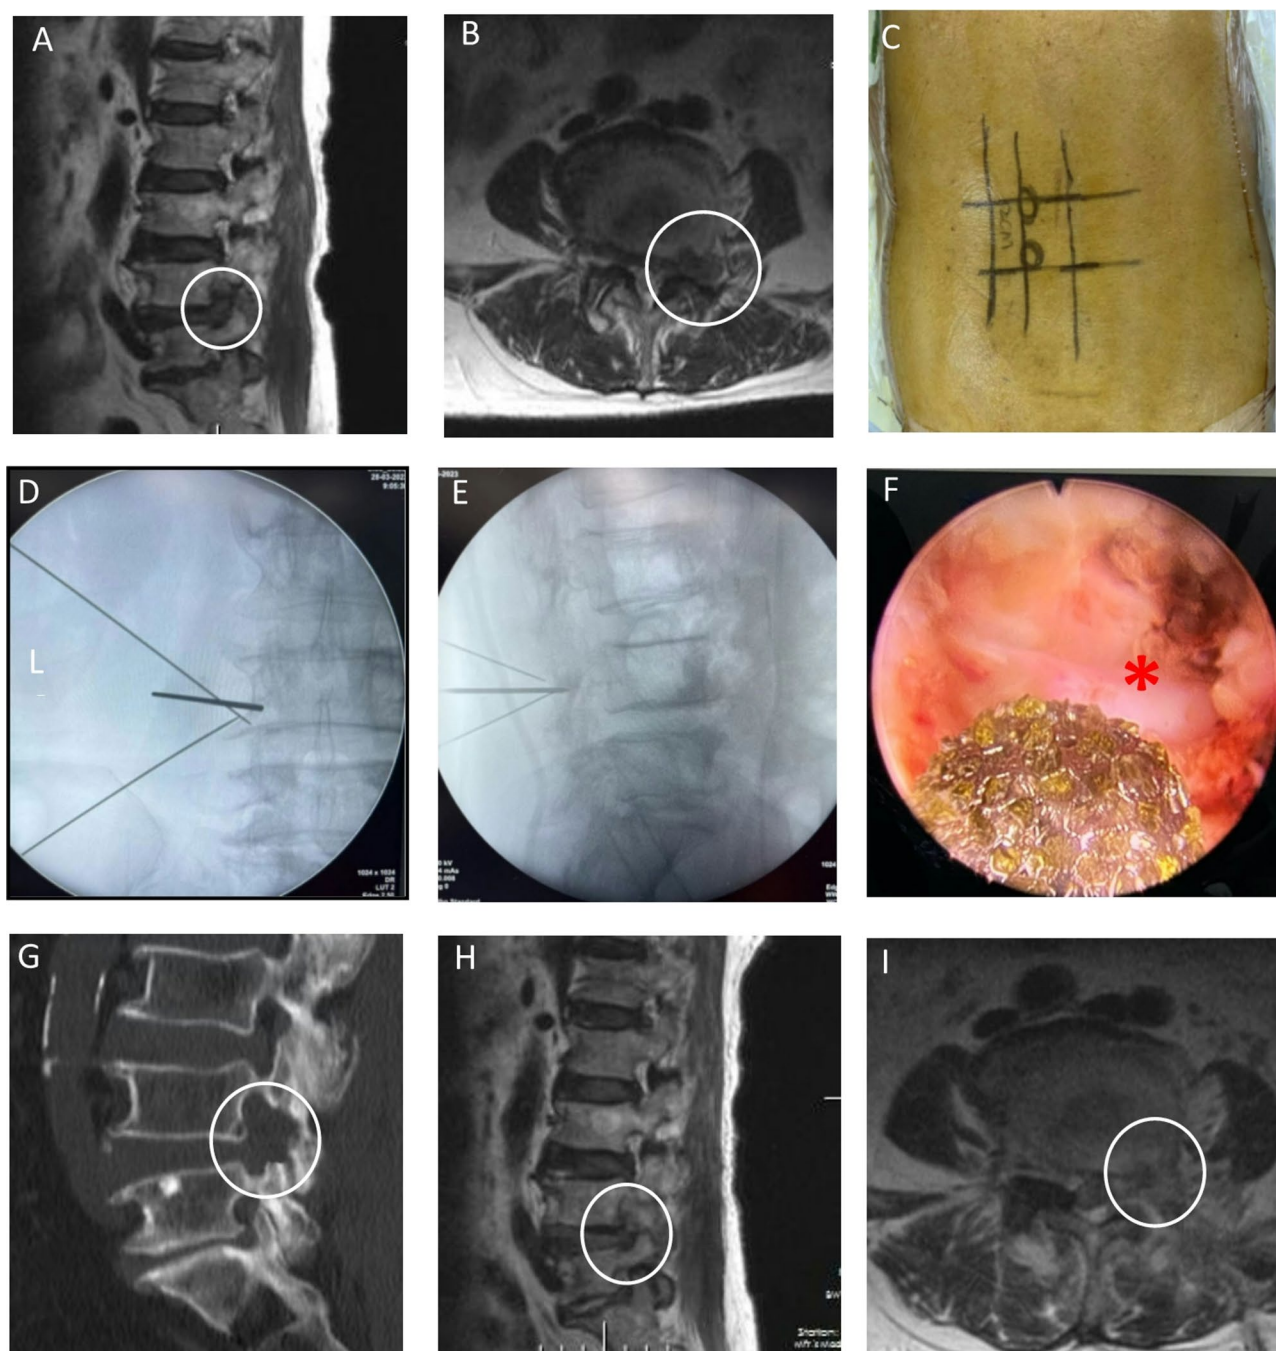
A 55-year-old male patient diagnosed with L4-5 far lateral lumbar disc herniation underwent the UBE discectomy. a and b, Preoperative magnetic resonance images (MRI) showing disc herniation (within the circle). c, The intraoperative incision was positioned about 2 cm lateral to the pedicle. d and e, Intraoperative Kirschner's needle localization on x-ray anteroposterior and lateral views; The needle was injected gradually so that the needle tip touched the isthmus of L4. f, Remove part isthmus of L4 and the tip of the L5 superior articular process to reveal the exiting nerve root (asterisk). g, CT image showed that decompression of the L4-5 foraminal area was sufficient. Partial bone of the L4 isthmus and a small amount of bone at the tip of the L5 superior articular process were removed (within the circle). h and i, MRI scans 12 months after the surgery showed the herniated nucleus pulposus was almost excised (within the circle)
